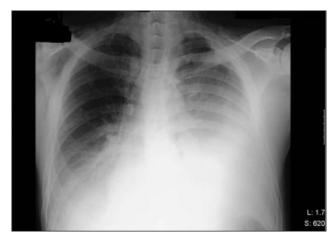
Chest x-ray showing bilateral effusion; the child with leptospirosis
